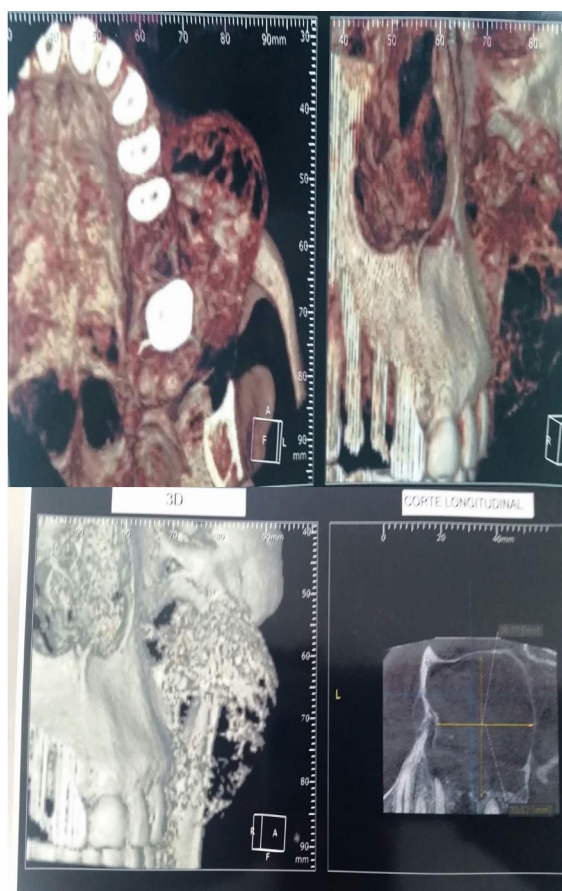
Computed tomography in 3D reconstruction. Solid lesion without aspects of calcification. Source: The autor.
